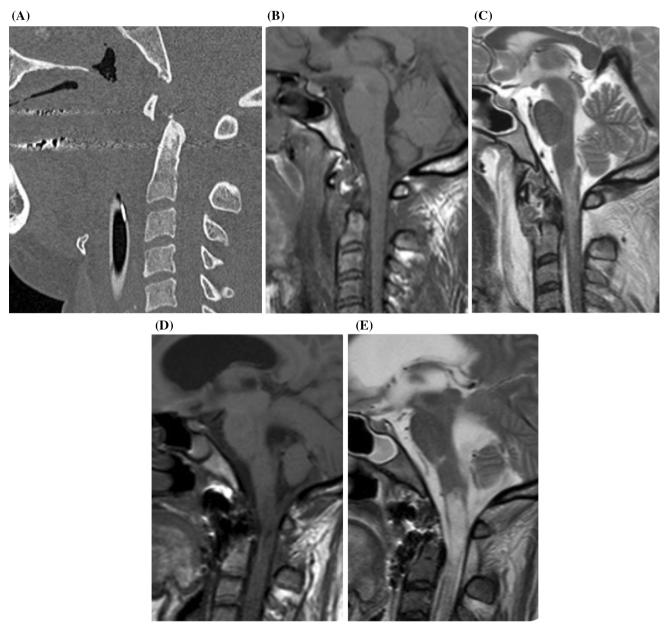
a CT MPR sagittal reconstruction: atlantoaxial dislocation with odontoid posteriorly dislocated. b, c MR, T1- and T2-weighted sagittal sections: bulbo-medullary junction, compressed by odontoid, shows swelling and T2-w hyperintense signal due to edema; note also
